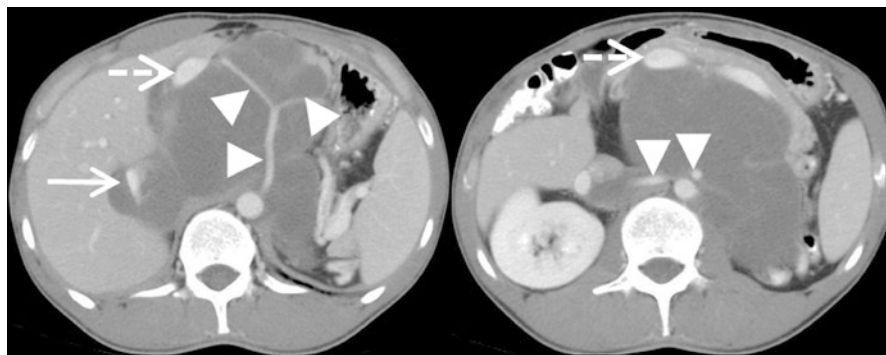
A 16-year-old boy with retroperitoneal ganglioneuroma (INSS stage 3, INRGSS L2). Contrast-enhanced transverse CT scan views. The tumour arises from the periaortic sympathetic chains and typically demonstrates low density with little enhancement. The mass encases (arrowheads) the major aortic branches (celiac, hepatic, splenic, superior mesenteric and the right renal arteries), as well as the inferior vena cava (arrow). The duodenopancreatic bloc and the portal vein (dotted arrow) are anteriorly displaced
